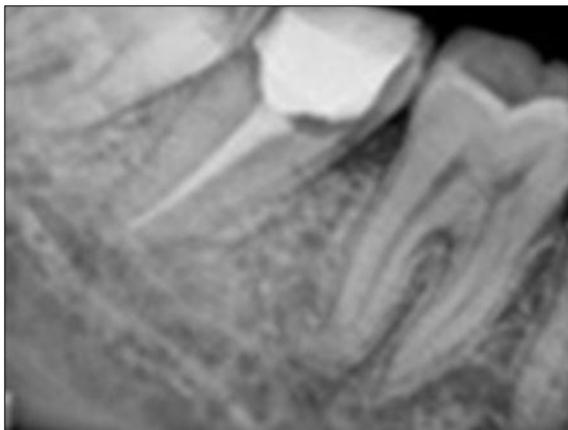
Post Obturation radiograph of Case 2
